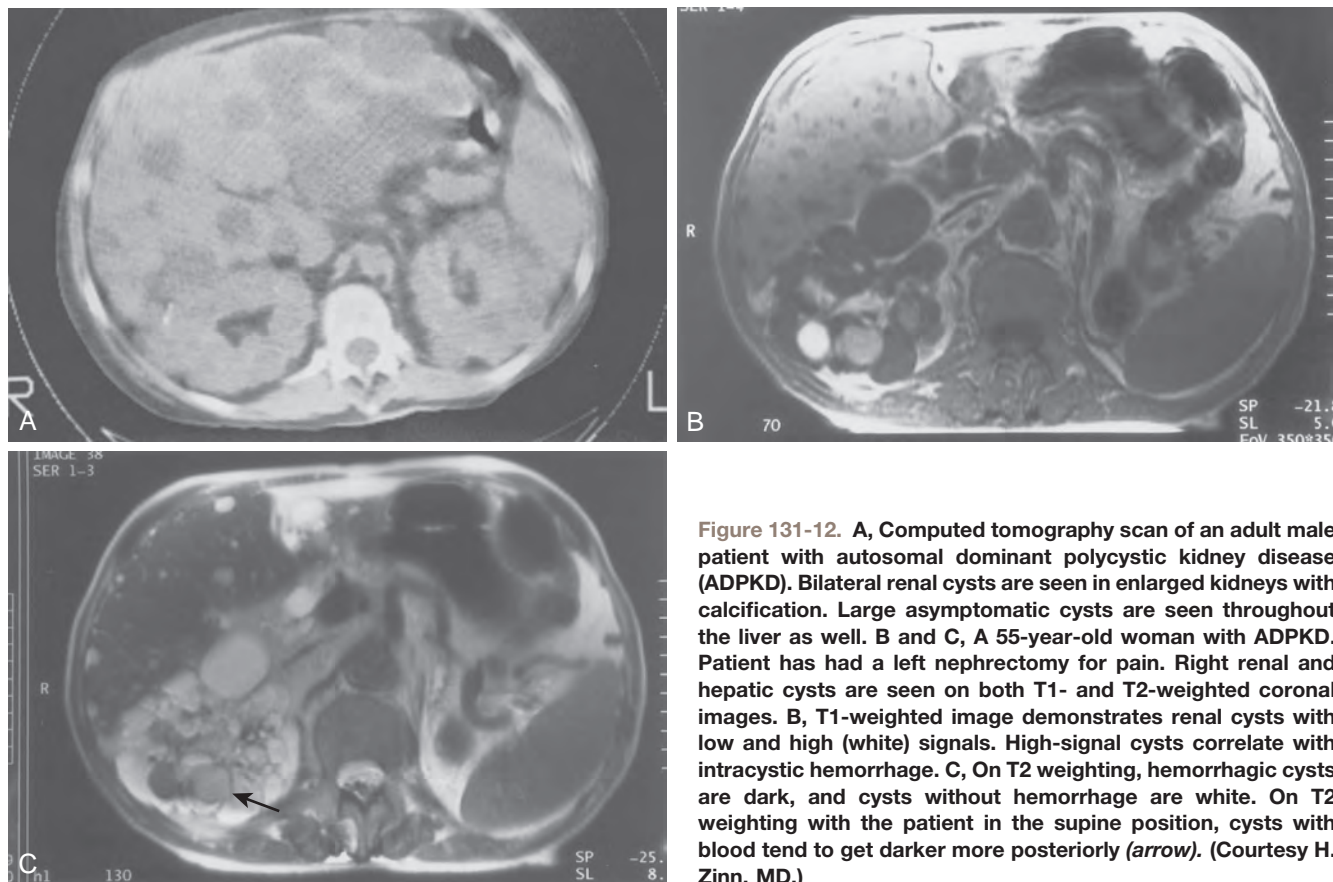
A, Computed tomography scan of an adult male patient with autosomal dominant polycystic kidney disease (ADPKD). Bilateral renal cysts are seen in enlarged kidneys with calcification. Large asymptomatic cysts are seen throughout the liver as well. B and C, A 55-year-old woman with ADPKD. Patient has had a left nephrectomy for pain. Right renal and hepatic cysts are seen on both T1- and T2-weighted coronal images. B, T1-weighted image demonstrates renal cysts with low and high (white) signals. High-signal cysts correlate with intracystic hemorrhage. C, On T2 weighting, hemorrhagic cysts are dark, and cysts without hemorrhage are white. On T2 weighting with the patient in the supine position, cysts with blood tend to get darker more posteriorly (arrow). (Courtesy H. Zinn, MD.)
